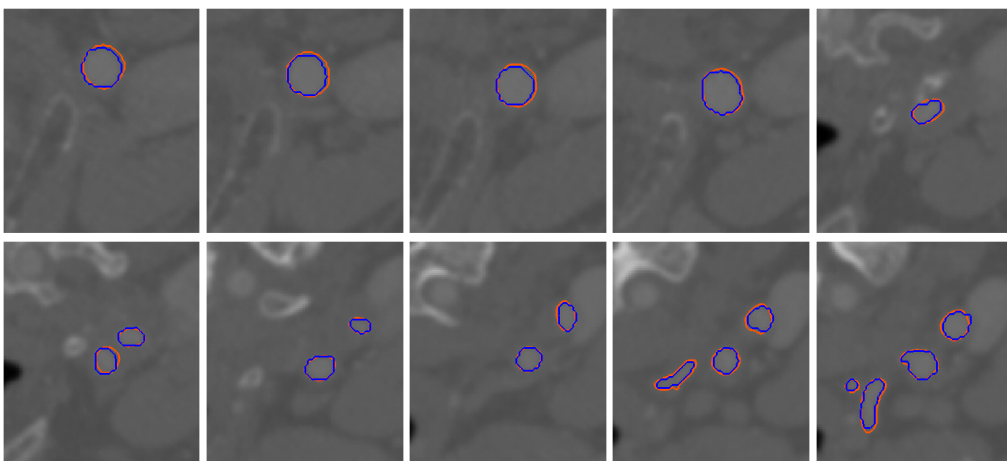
Comparison of geometry segmented from CT image dataset 6 using image slices taken along z-axis direction: blue - manual, orange - GPF deformable model.
